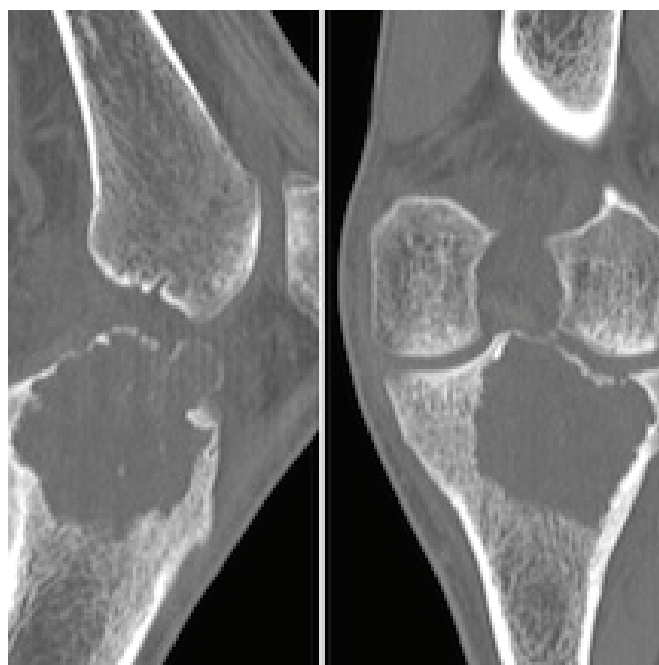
Computed tomography images (sagittal and coronal views showing the subchondral extent of the tumour).
